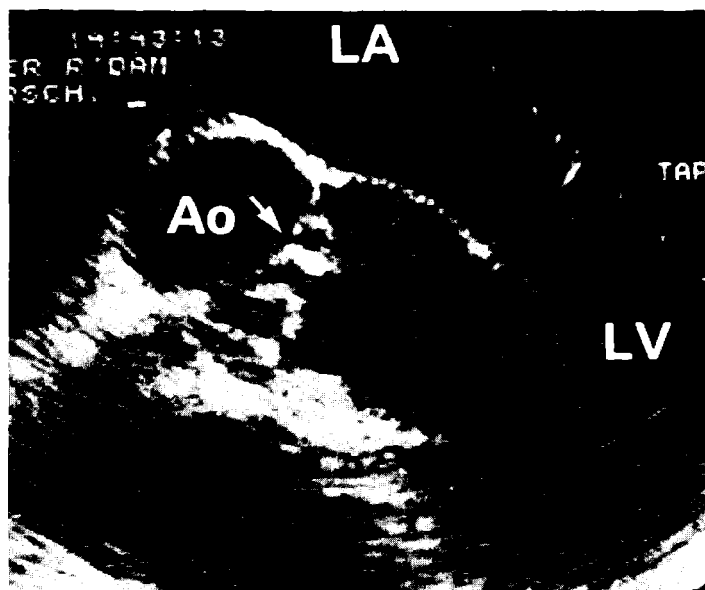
Transesophageal echocardiographic diastolic still frame from a patient with native aortic valve endocarditis (Table II, case 5) showing a perforation in the aortic cusp (arrow) with a vegetation. This was not detected by the precordial approach. Ao = aorta; LA = left atrium; LV = left ventricle.
